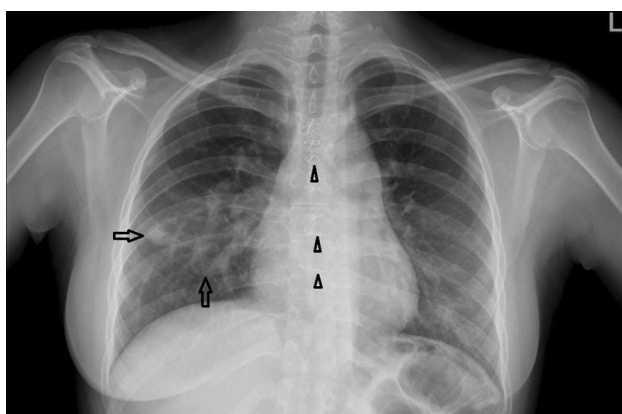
Posteroanterior chest X-ray shows two dilated and curved tubular structures (arrows) coursing and converging toward the right pulmonary hilus, anomalously. Notice midline sternal wires (arrow heads) indicating previous cardiothoracic surgery
